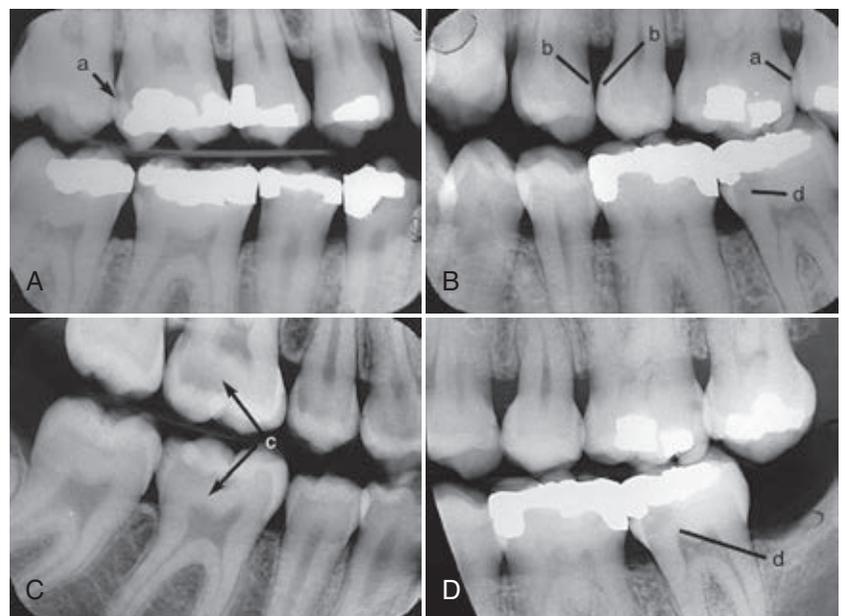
Caries can be diagnosed radiographically as translucencies in the enamel or dentin. A and B, Proximal caries tends to occur bilaterally (a) and on adjacent surfaces (b). C, Occlusal caries (c). D, Recurrent caries gingival to an existing restoration (d). This same recurrent caries (d) also is shown in B.
